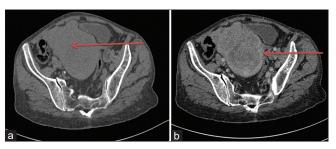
(a and b) Axial CT scan section showing a tumor of the uterine body, well-limited, spontaneously isodense, and enhancing heterogeneously after the injection of a contrast product.
